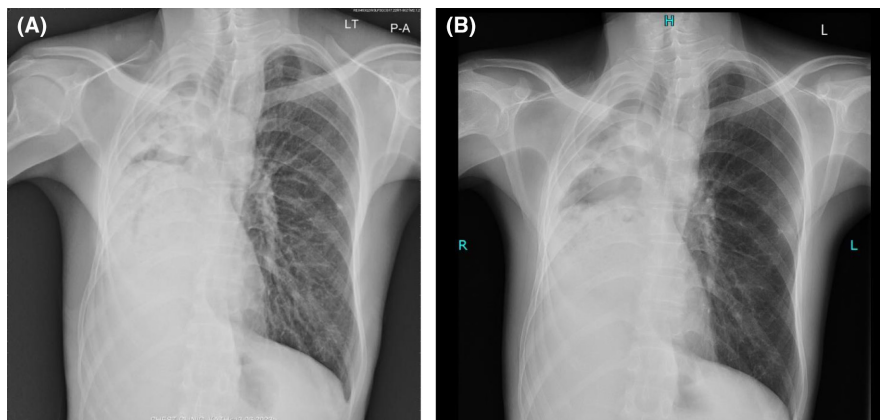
(A) Chest x-ray showing trachea deviation to the right, reduced rib spaces on the right, homogeneous opacification on the right hemithorax with compensatory hyperinflation on the left. Pretreatment x-ray for case 2. (B) Post-treatment chest x-ray for case 2 showing no significant improvement compared to the pre-treatment chest x-ray. There is mediastinal herniation to the right with crowding of the right ribs and hyperinflation on the left.
